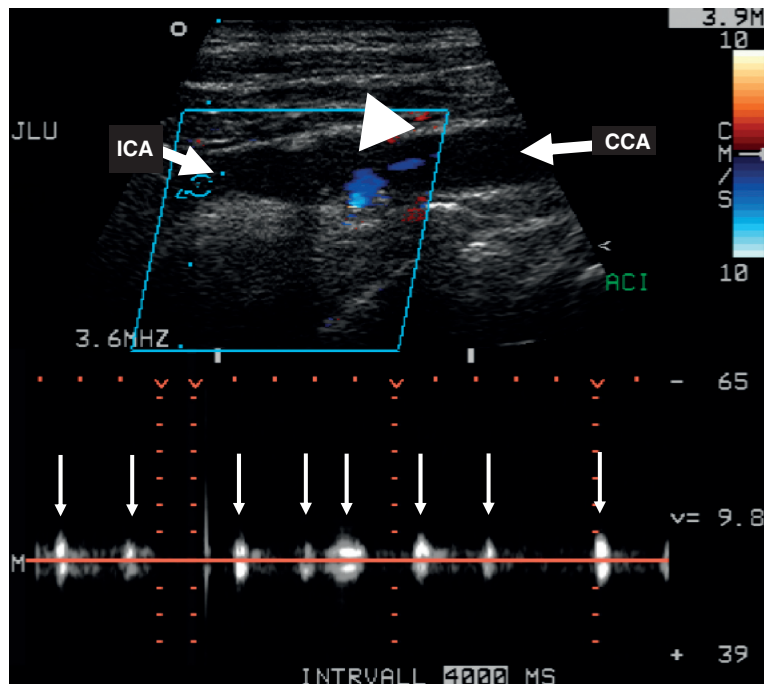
Occlusion of the internal carotid artery. Doppler spectra analysis reveals a typical preocclusive flow pattern within the proximal part of the internal carotid artery (arrows). ICA = internal carotid artery; CCA = common carotid artery; arrow-head = carotid bulb.
